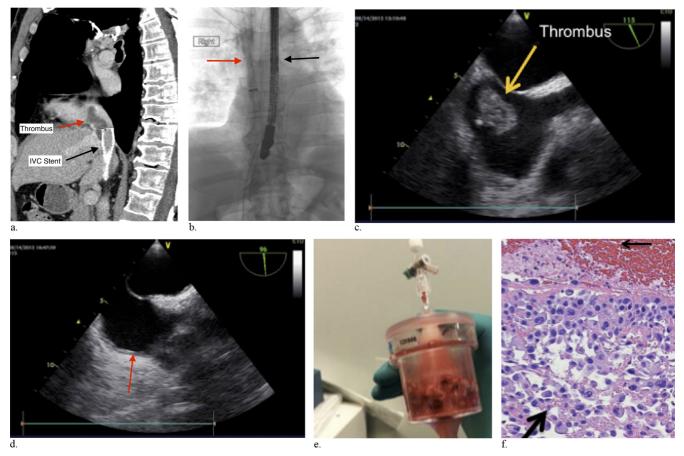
A 62-year-old man with metastatic melanoma to the heart and inferior vena cava. (a) Computed tomography image obtained before the procedure demonstrates extensive thrombus (red arrow) extending through an inferior vena cava stent (black arrow) into the right atrium. (b) Spot radiograph obtained during the procedure shows transesophageal echocardiographic probe (black arrow) and right internal jugular thrombectomy approach (red arrow). Echocardiograms obtained (c) before and (d) after AngioVac thrombectomy demonstrate complete removal of atrial thrombus (yellow arrow in c). Atrium is free of thrombus after removal (red arrow in d). (e) Suctioned thrombus and (f) pathology-proven melanoma (arrow). IVC = inferior vena cava.
